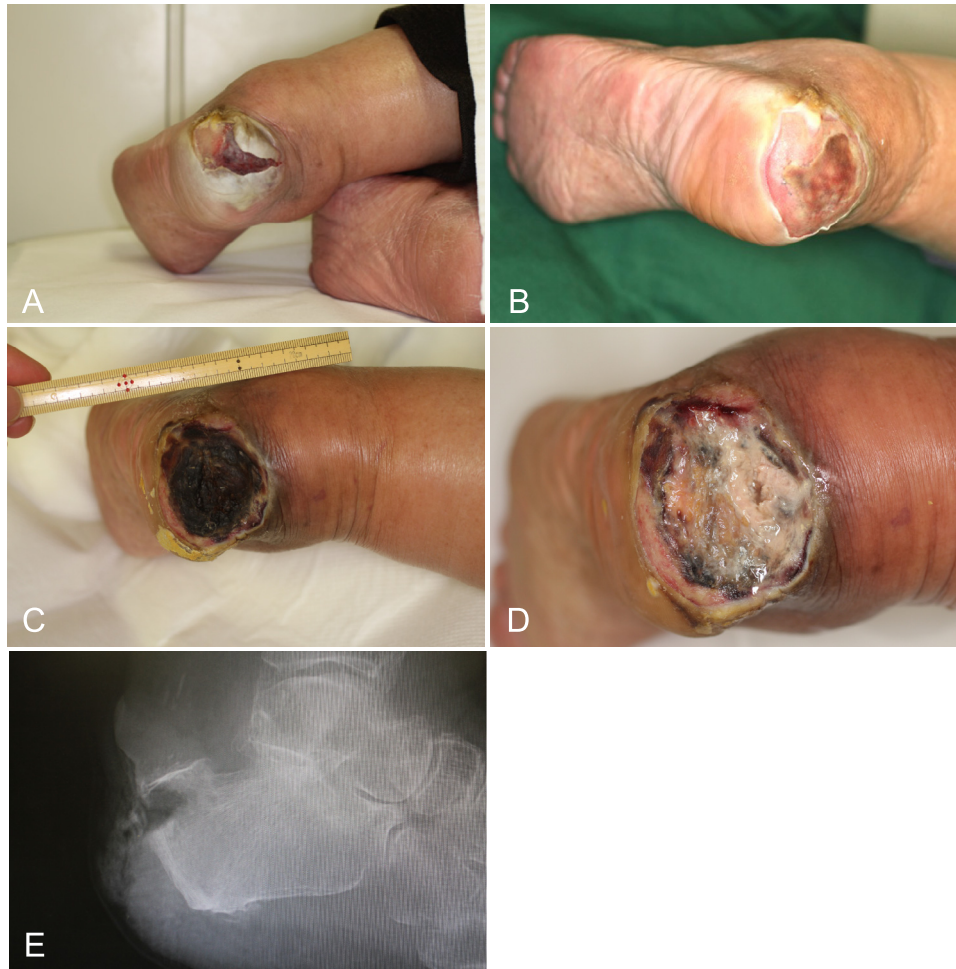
Clinical findings before admission. (A) Posterior aspects of the calcaneal region at the first visit. (B) Local findings 1 week after the first visit. (C) Local findings 4 weeks after the first visit. Black necrotic tissue was observed on the surface of the lesion. (D) Local status after removal of the necrotic tissue. The surface of the calcaneal bone could be seen on the cranial side of the ulcer. (E) Plain radiograph (lateral view) of the left calcaneus just before admission. The outer cortex of the left calcaneus had been destroyed.
